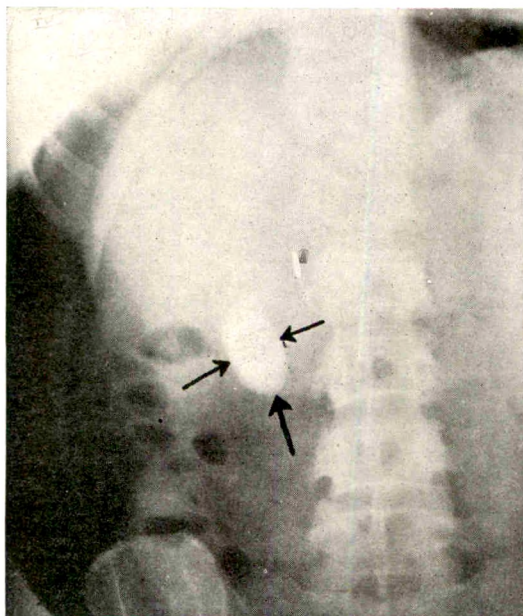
Posteroanterior roentgenogram, showing gall-bladder well filled.
